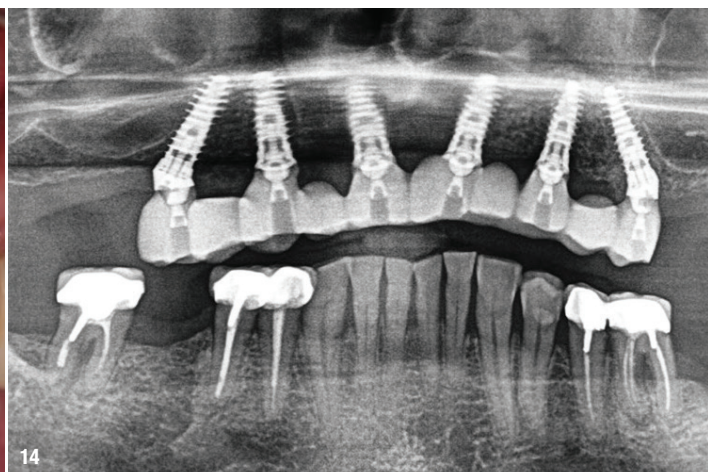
Post-placement radiograph of the temporary prosthesis.
